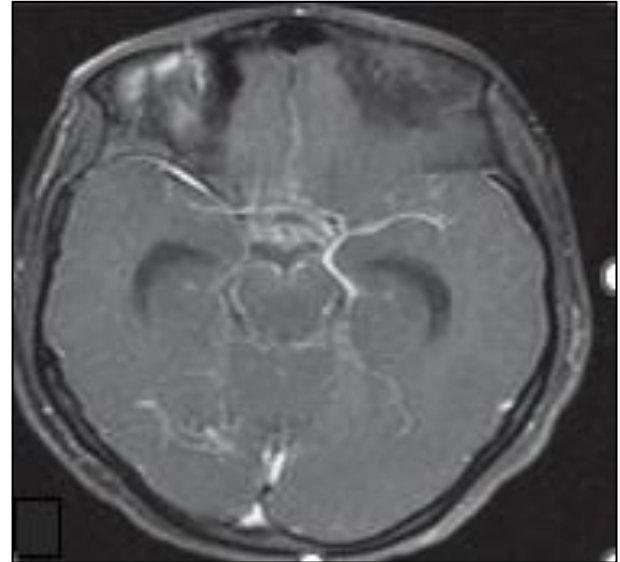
MRI brain showing basal meningeal enhancement.
